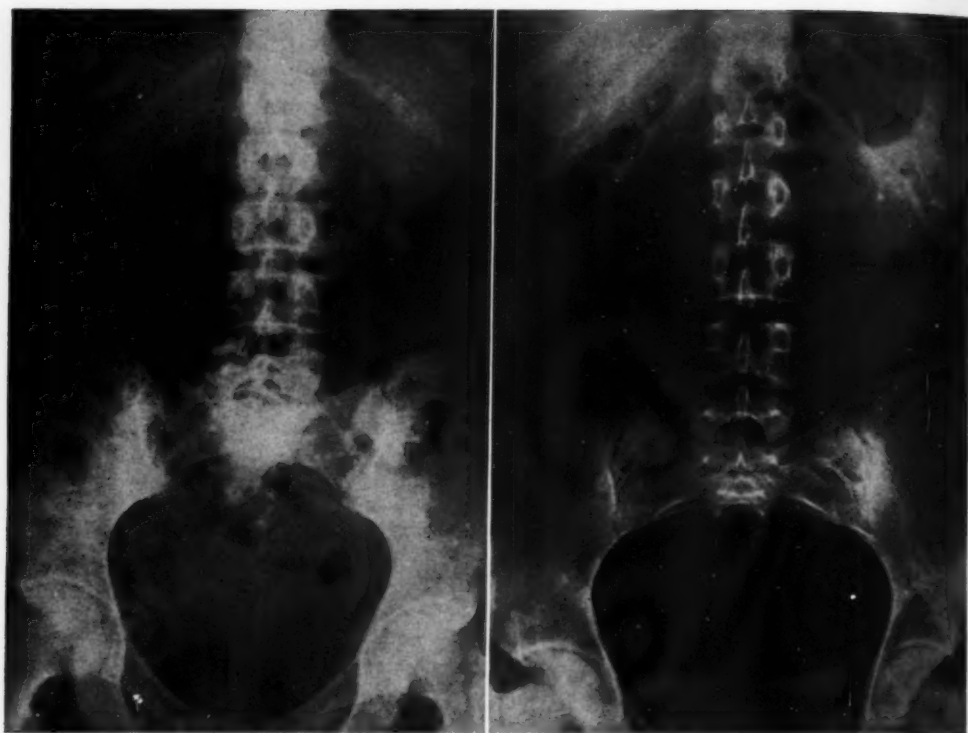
(left). Urogram in a patient with chronic glomerulonephritis. The urea clearance was 10 per cent of normal. There is no roentgen evidence of diodrast clearance at one hour.
